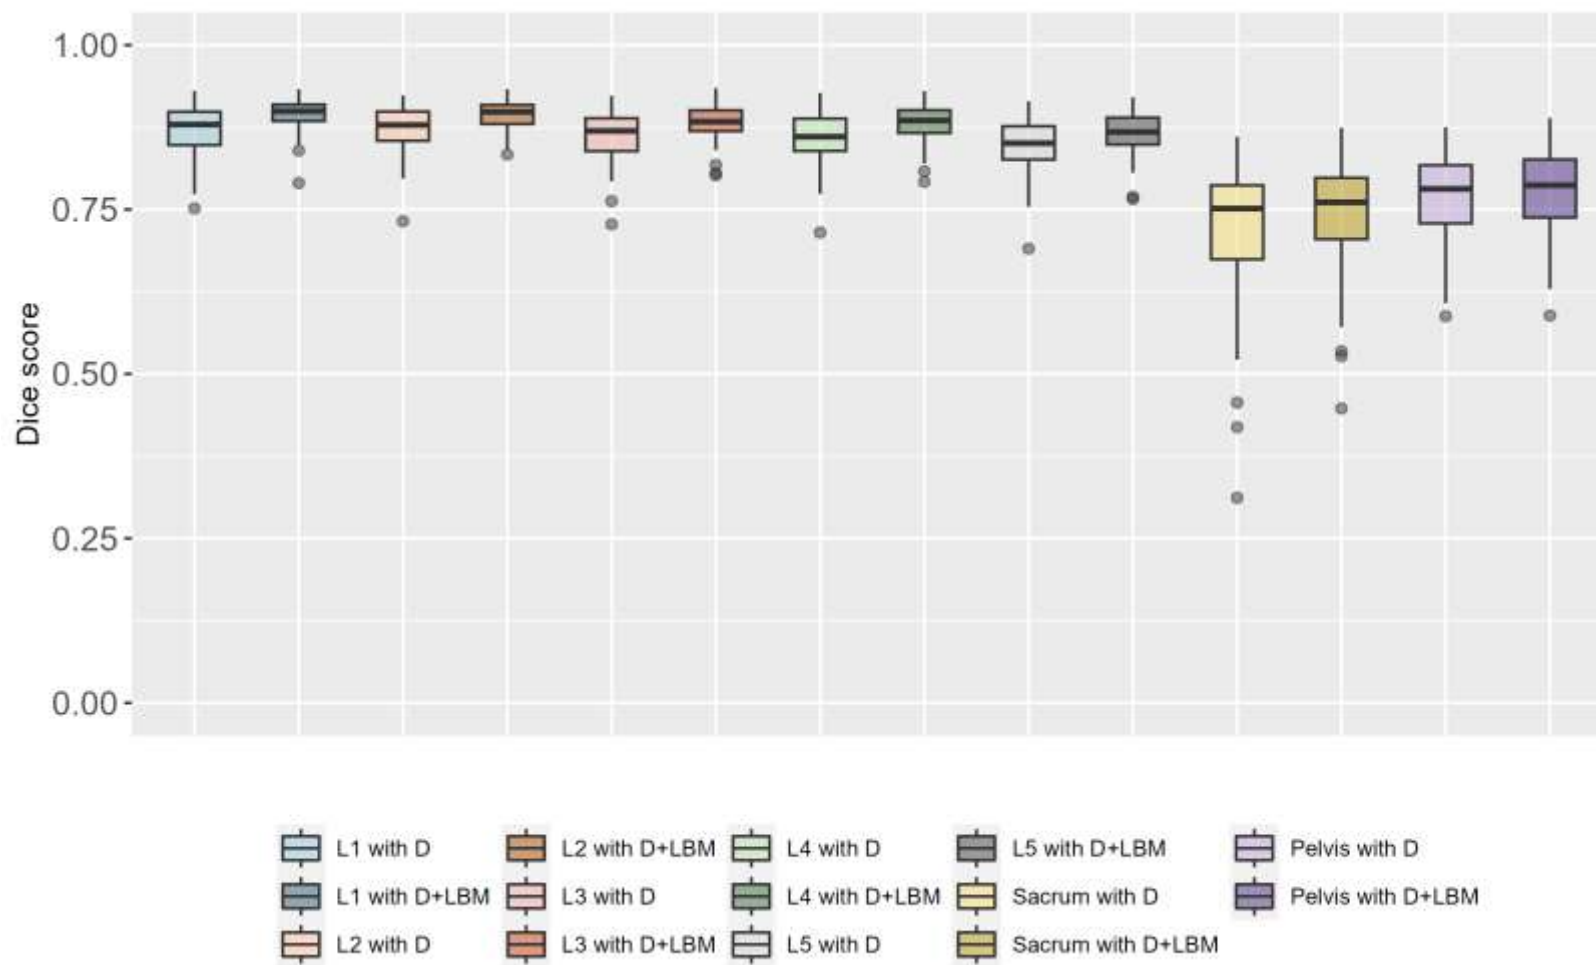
Dice score between CT reconstructed and SSM predicted single bones for only with demographics (D) and with demographics and linear bone measurements (D+LBM)
